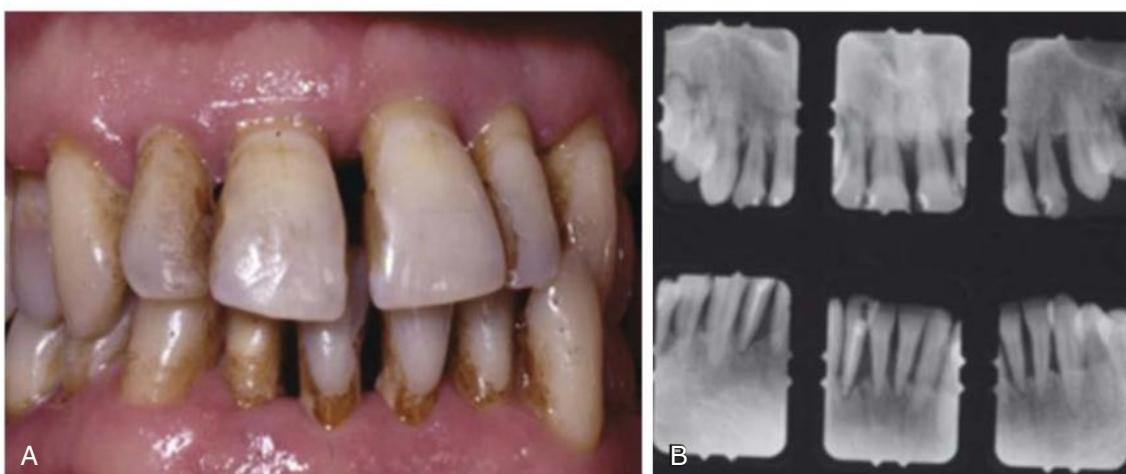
Clinical (A) and radiographic (B) images of a patient suffering from periodontitis showing the classical clinical signs of the disease. The clinical signs include signs of inflammation of the gingiva, deepening of periodontal sulcus (becoming a pocket), and the presence of deposits. Radiographically, bone loss is characteristic of periodontitis, and in the example shown (B) there is bone loss all the way up to the apical third of the root of the anterior dentition.
